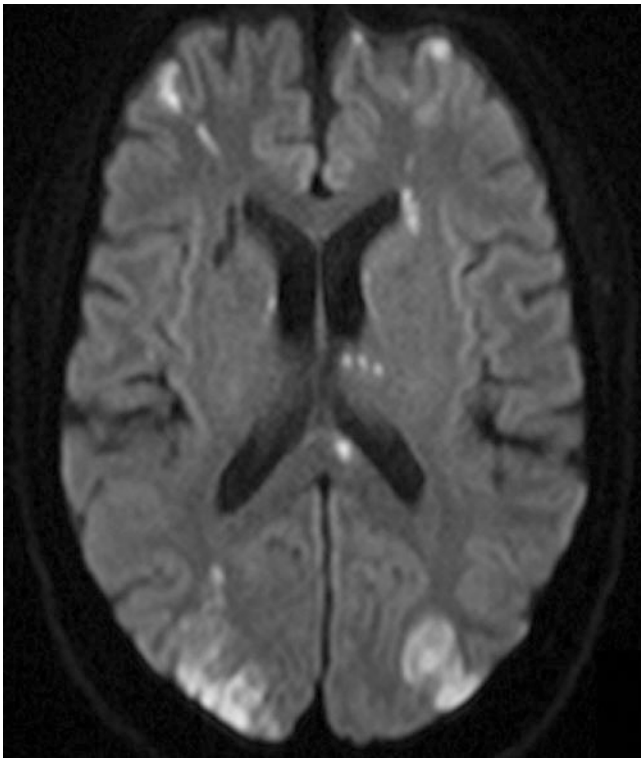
External cortical borderzone infarction. DWI shows acute infarctions in the bilateral frontal lobes at the ACA/MCA borderzone and bilateral parieto-occipital lobes at the MCA/PCA borderzone. MRA of the head and neck demonstrates no large vessel occlusion or stenosis (not shown). These are likely due to embolic phenomenon, which are further supported by the small infarctions in the basal ganglia, thalamus, and splenium of corpus callosum
